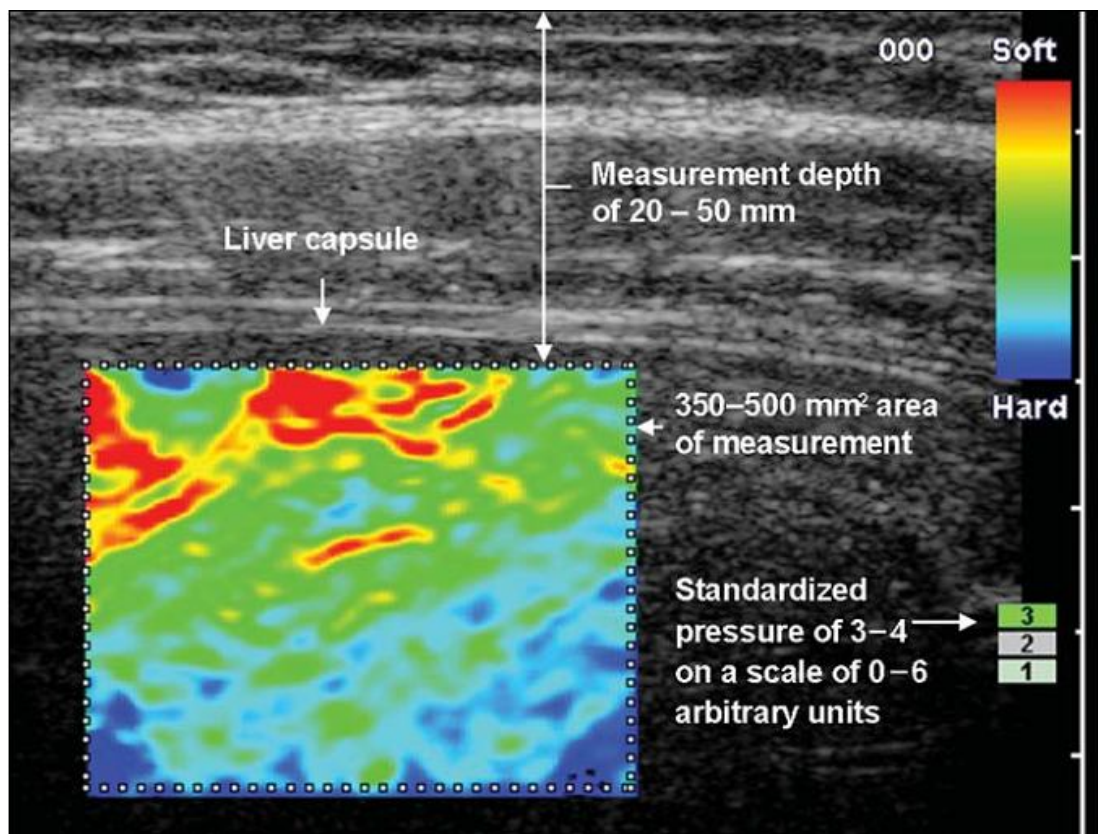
RTE for liver stiffness measurement using conventional B-mode ultrasound probe for compression. It shows the stiffness distribution of tissue coded with color, red for soft tissue and blue for hard tissue. (Friedrich-Rust et al. 2007)
